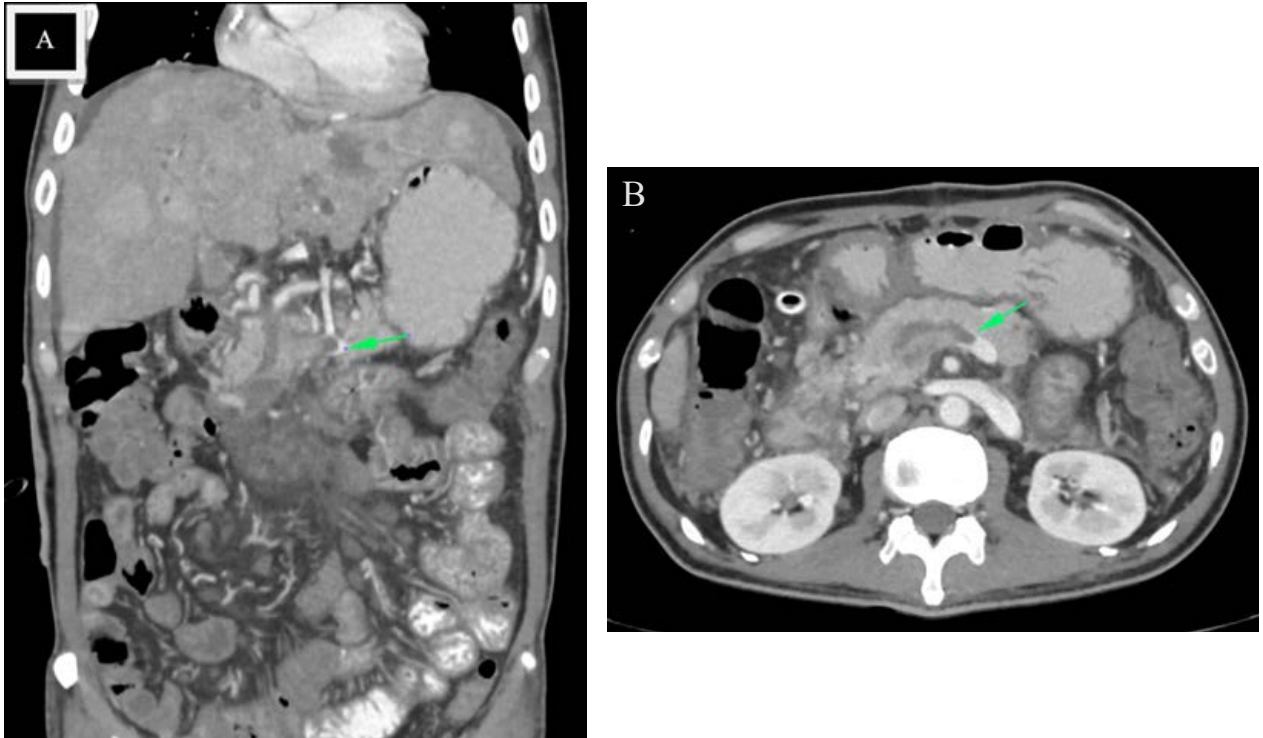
Coronal (A) and transverse (B) contrast-enhanced CT image demonstrates a filling defect within the lumen of the splenic vein (arrow), consistent with thrombosis.
